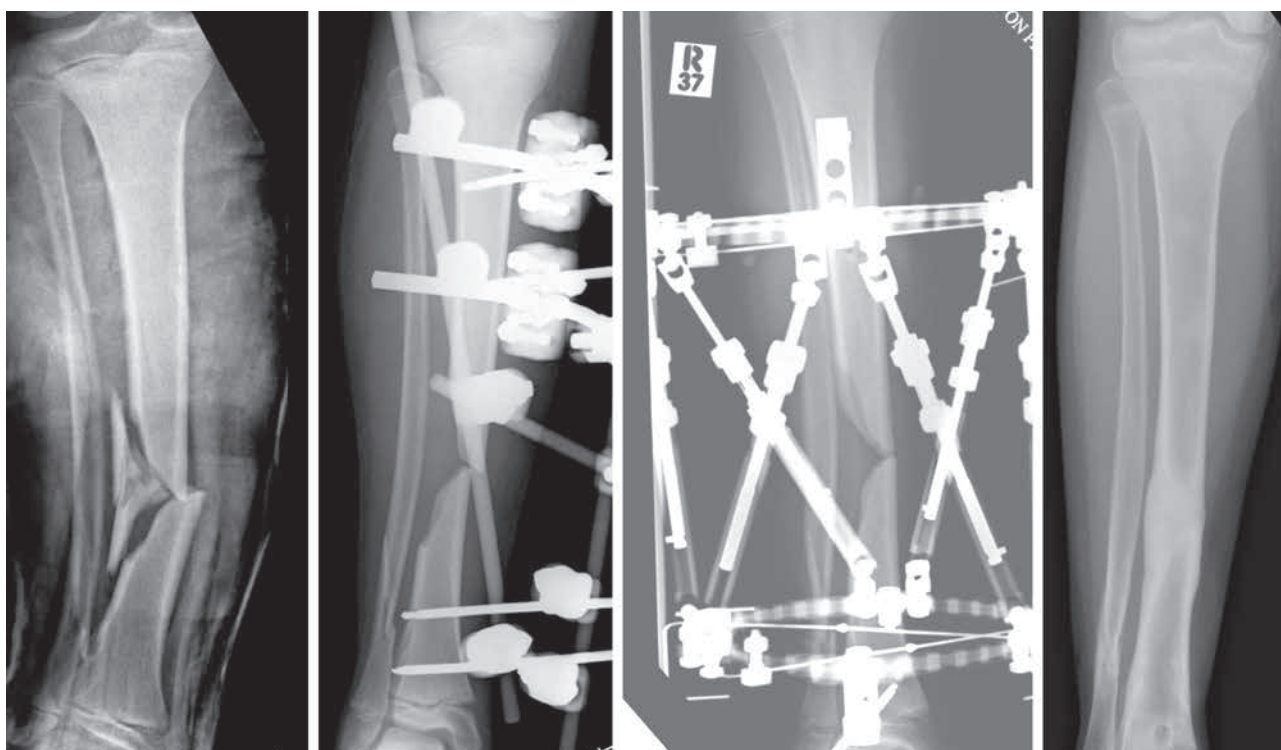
Plain AP radiograph of an 11 year old boy with an isolated grade IIIIB open right tibial fracture, following pedestrian versus car trauma. Initially managed with a mono-linear external fixator and definitive soft tissue coverage with a local flap. Converted to a circular Taylor Spatial Frame at 6 weeks. Plain radiograph at 1 year follow-up with full union.
